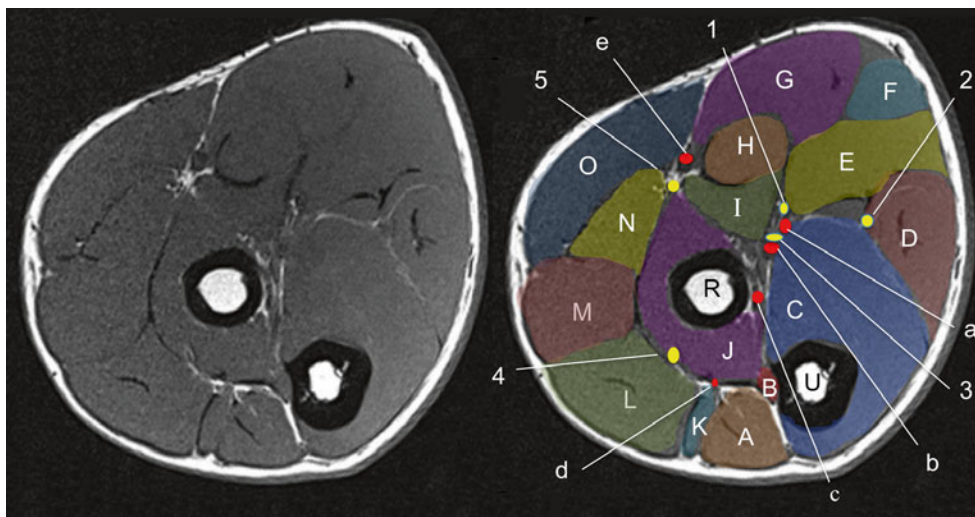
MRI axial image of the distal forearm. *A* anconeus muscle, *B* extensor pollicis longus muscle, *C* flexor digitorum profundus muscle, *D* flexor carpi ulnaris muscle, *E* flexor digitorum superficialis muscle, *F* palmaris longus muscle, *G* flexor carpi radialis muscle, *H* pronator teres muscle (humeral head), *I* pronator teres muscle (ulnar head), *J* supinator muscle, *K* extensor digiti minimi muscle, *L* extensor
